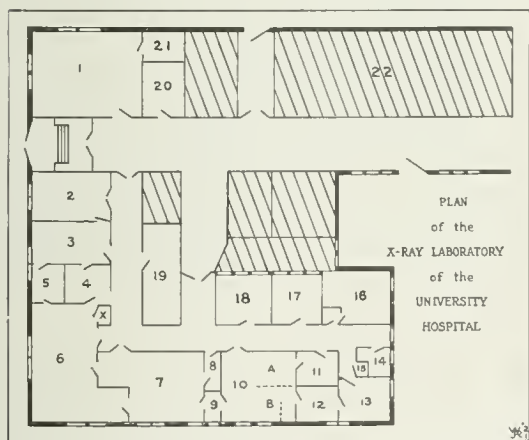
(1) Demonstration and lecture room; records kept here also. (2) Private waiting-room. (3) Private office. (4) Examining and dressing room. (5) Lavatory. (6) General roentgenographic room. (7) Fluoroscopic room. (8) Dressing room. (9) Treatment control room. (10) Roentgen therapy room. (11) Dressing-room. (12) Room used for making lantern slides or making reductions. (13) Chemical room. (14) Lavatory (15) Service room. (16) Dark room. (17) Photographic and radium treatment room. (18) Small roentgenographic room. (19) Demonstration and film filing room. (20) Film filing room. (21) Supplies. (22) Room reserved for deep therapy.
